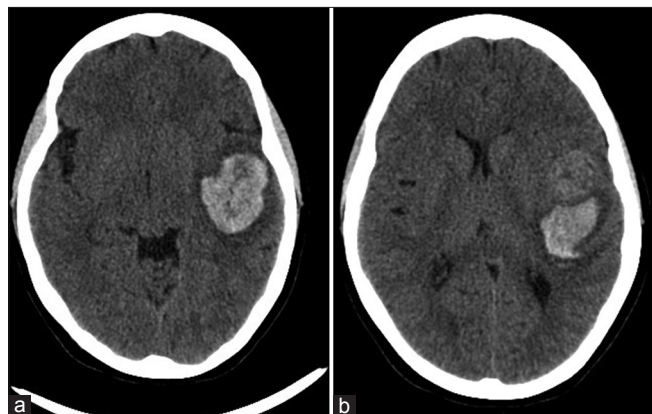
(a) Admission computed tomography scan showing temporal lobe hemorrhage. (b) Admission computed tomography scan: Note nodular hyperdensity in front of hemorrhage
